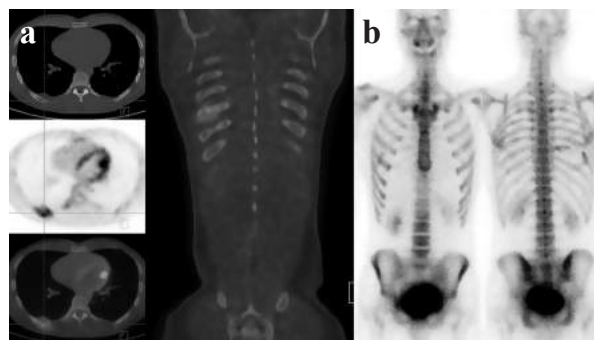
A 30-year-old man with right-sided nonseminoma (PH: mature teratoma+immature teratoma+embryonal cell carcinoma with elements of Yolk sac differentiation+trophoblastic cells). Initial treatment – right orchiectomy followed by chemotherapy. Referred to PET for evaluation of elevated tumor markers. a) ^{18}F -FDG PET-CT scan revealed FDG-avid focus in the posterior part of the right 8th rib with local thickening of the pleura (SUV max 4.8). b) bone scintigraphy with $^{99\text{m}}\text{Tc}$ -diphosphonate shows osteolytic lesion of the same rib. He was operated (resection of the rib), PH: Mature teratoma with elements of immature teratoma.
